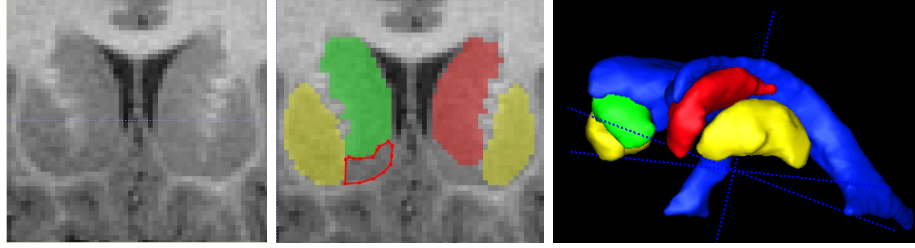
Coronal slice of the caudate: original T1-weighted MRI (left) and segmented (middle). Right and left caudate are shown shaded in green and red; left and right putamen are sketched in yellow, laterally exterior to the caudates. Nucleus accumbens is sketched in red outline. Note the lack of contrast at the boundary between the caudate and the nucleus accumbens, and the fine-scale cell bridges between the caudate and the putamen. At right is a 3D view of the segmented caudate and putamen relative to the ventricles. Figure courtesy of Rachel Gimpel.
